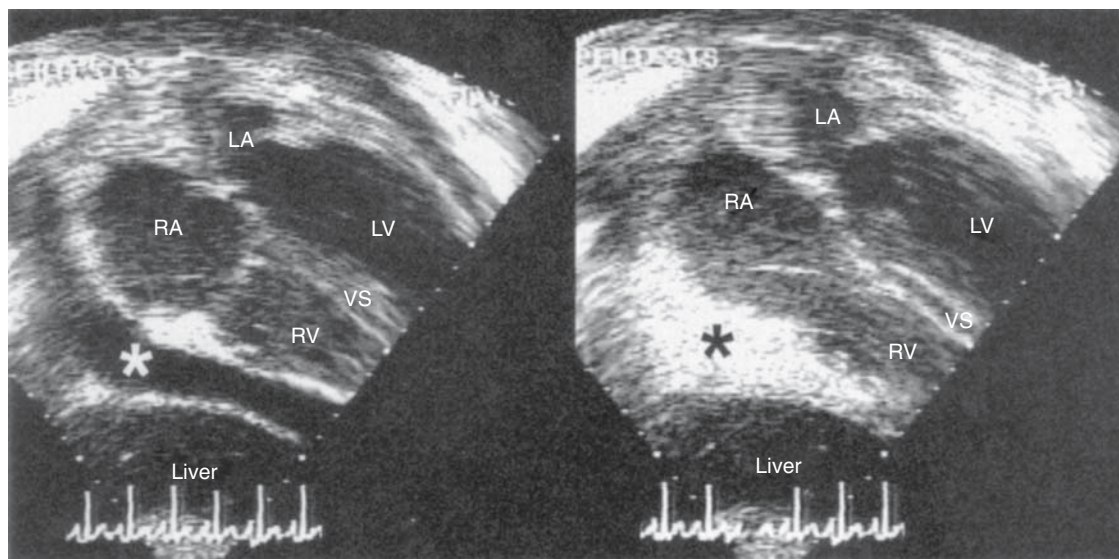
Echocardiographically monitored pericardiocentesis. (A) Before injection. (B) After injection. Bubble contrast opacifies the effusion (*).
